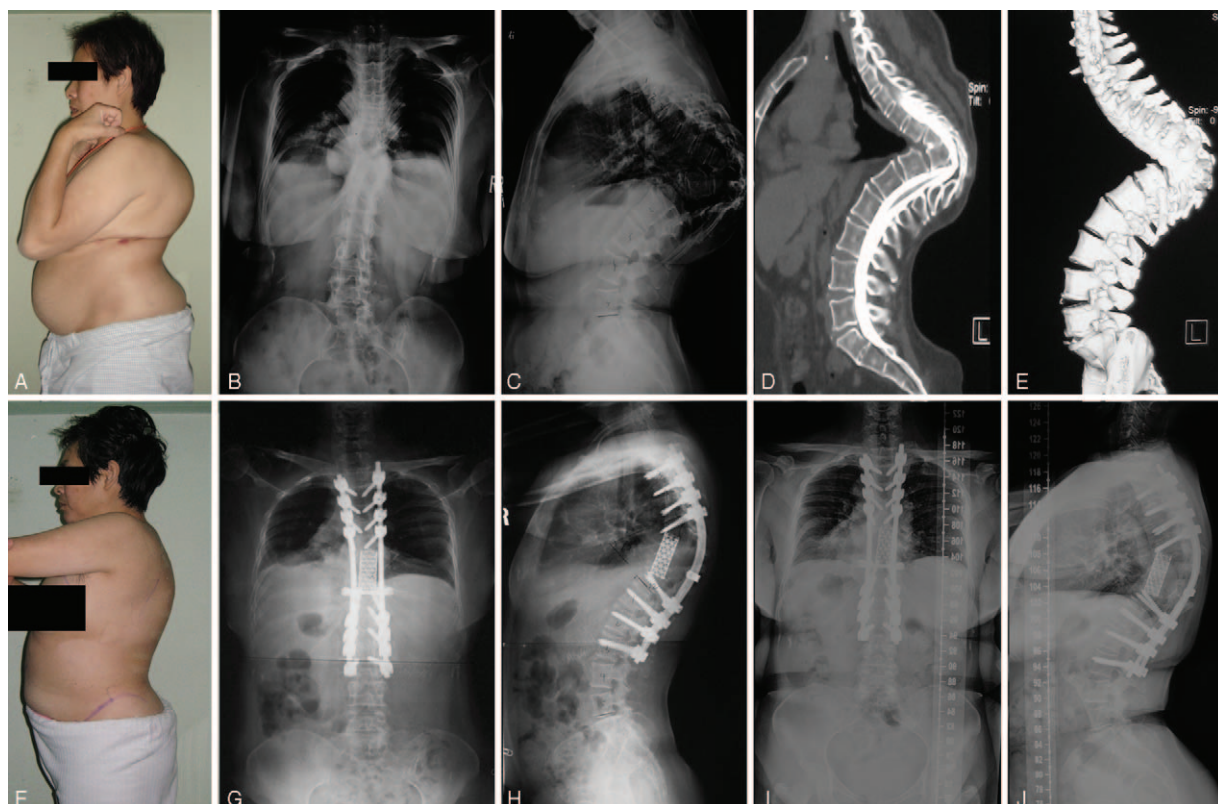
Images of a 52-year-old female patient with a kyphosis for Pott disease. She underwent a pVCR procedure at T7–T11 with the fusion level of T3–L3. (A) Preoperative gross photo. (B, C) Preoperative standing coronal and sagittal long-cassette radiographs with the local kyphosis angle of 127° . (D, E) Preoperative sagittal CT myelography (CTM) and 3D CT reconstruction images, that shows the spinal cord compression. (F) Postoperative gross photo. (G, H) Postoperative standing coronal and sagittal long-cassette radiographs with the local kyphosis angle of 60° and the correction rate of 64.1%. (I, J) The standing coronal and sagittal long-cassette radiographs at last follow-up. 3D CT indicates three-dimensional computed tomography.
